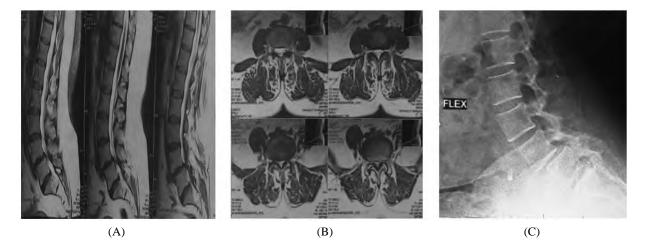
MRI lumbar spine sagittal (a) and axial (b) views showing L4-5 degenerative spondylolithesis with spinal canal stenosis at level of L 4-5, and preoperative X-ray lateral view (c).
